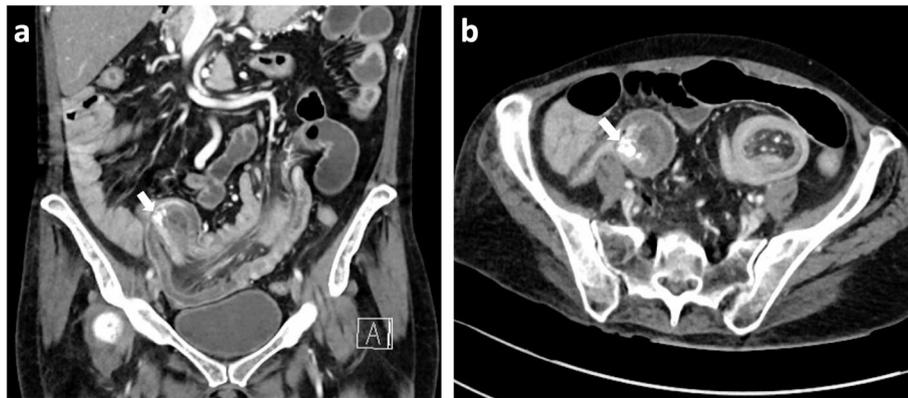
Coronal (a) and axial (b) contrast-enhanced portal venous phase CT images showing an extremely long ileocolic intussusception with resultant small bowel obstruction. The lead point is a 17 mm calcified mass in the ileum (arrows)
